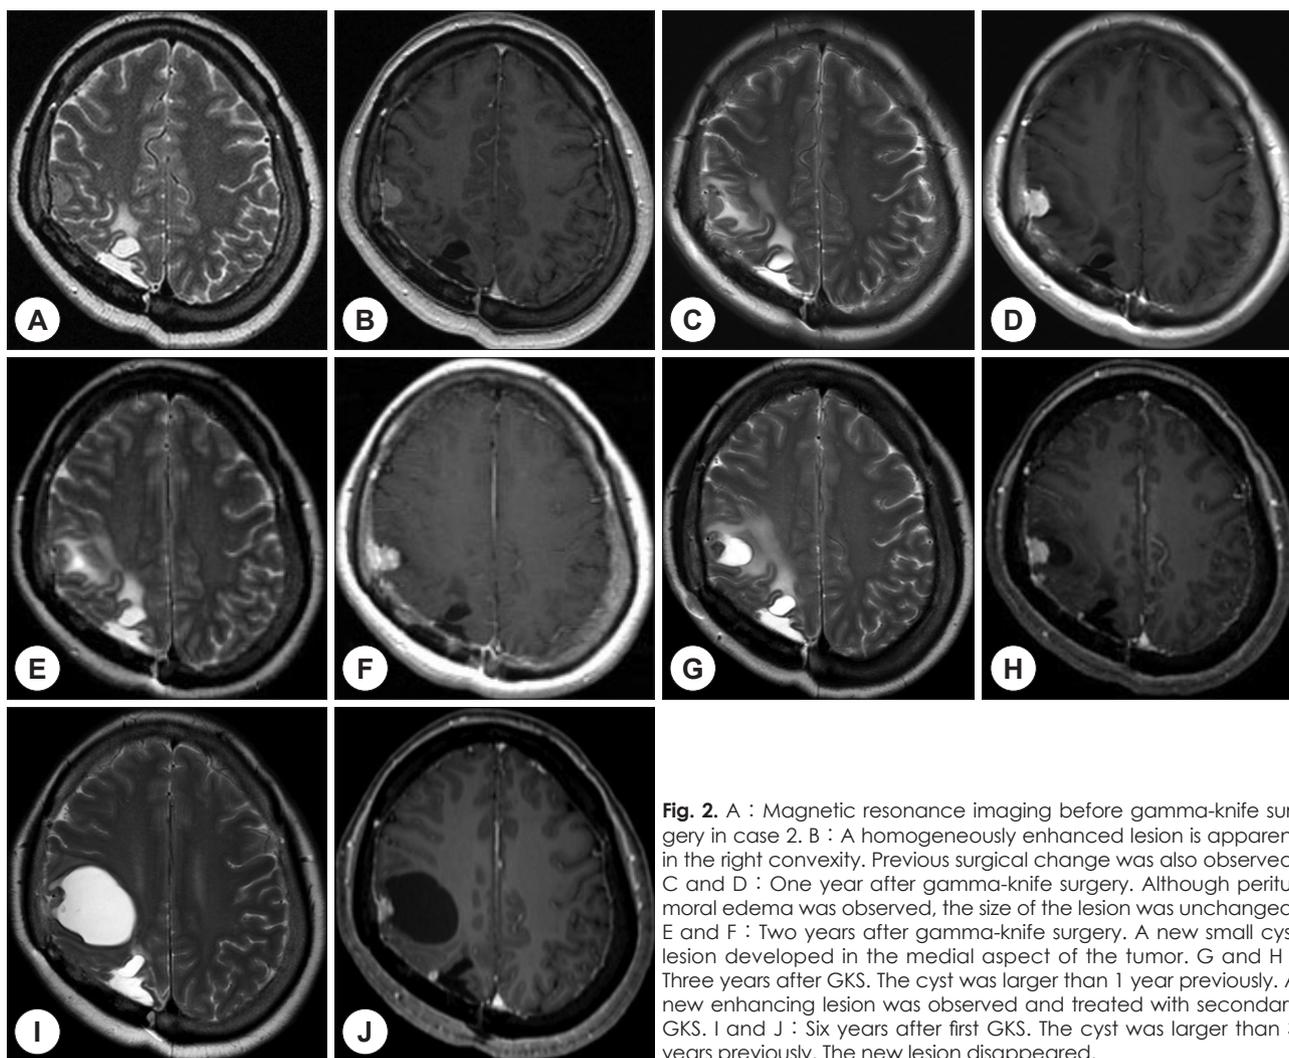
A : Magnetic resonance imaging before gamma-knife surgery in case 2. B : A homogeneously enhanced lesion is apparent in the right convexity. Previous surgical change was also observed. C and D : One year after gamma-knife surgery. Although peritumoral edema was observed, the size of the lesion was unchanged. E and F : Two years after gamma-knife surgery. A new small cyst lesion developed in the medial aspect of the tumor. G and H : Three years after GKS. The cyst was larger than 1 year previously. A new enhancing lesion was observed and treated with secondary GKS. I and J : Six years after first GKS. The cyst was larger than 3 years previously. The new lesion disappeared.
